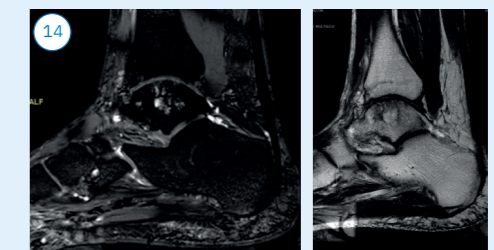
cartilage gradient MRI 3 years postoperatively. Signs of restoration of the articular surface are seen in the injured area, with persistence of a cystic image in the subchondral bone.
